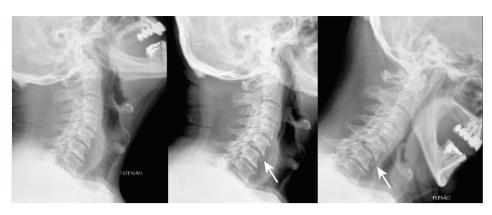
Imaging – dynamic X-rays Dynamic X-ray views of a 65-yearold male with a traumatic C5–C6 disc lesion. Note the instability at the disc level with anterolisthesis of C5 over C6 on hyperflexion.
